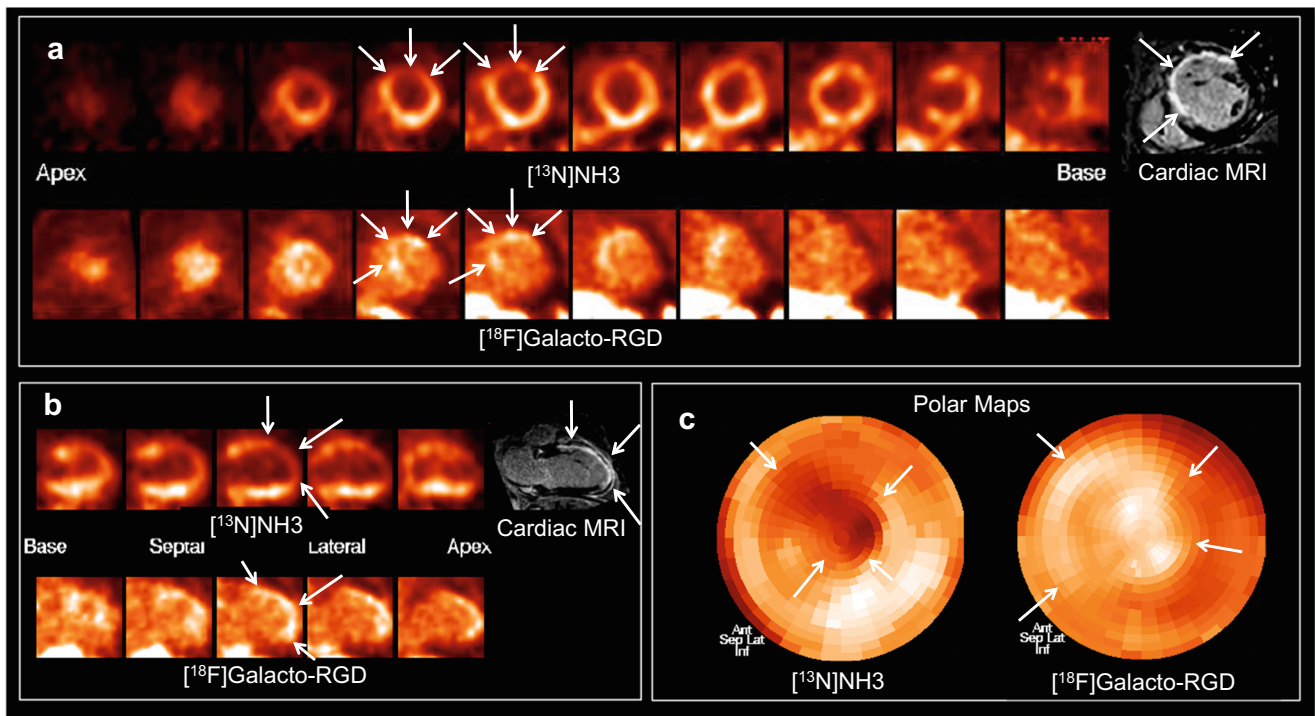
Patterns of $[^{18}\text{F}]\text{Galacto-RGD}$ uptake in myocardial infarction. $[^{13}\text{N}]\text{NH}_3$ and $[^{18}\text{F}]\text{Galacto-RGD}$ PET as well as late enhancement cardiac MRI is shown (A: short axis; B: vertical long axis; C: polar maps). A large area of infarction with predominantly transmural contrast enhancement is shown in cardiac MRI in the anterior and anteroseptal wall with severely impaired blood flow in $[^{13}\text{N}]\text{NH}_3$ PET
